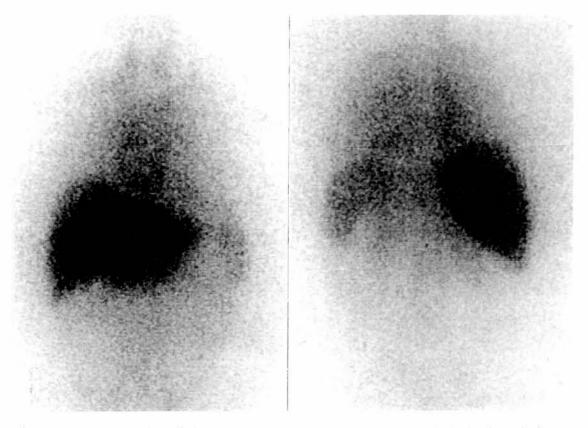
Anterior (*left*) and posterior (*right*) views of whole body scintigrams taken 24 h after intravenous injection of 131 I-labelled human SAP in the individual marked Ψ in Figure 3.6. There is massive uptake of tracer in the liver with no significant retention elsewhere and very low blood pool background, compatible with massive hepatic amyloidosis.
